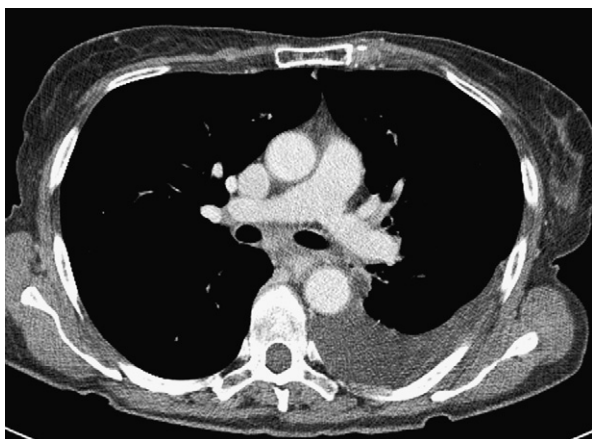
Contrast-enhanced CT of the chest showing left sided pleural effusion and the presence of mediastinal lymphadenopathy in a 46 year-old patient with RDD (patient #5 in Table 2). Diagnosis of RDD was established by mediastinal lymph node biopsy.
